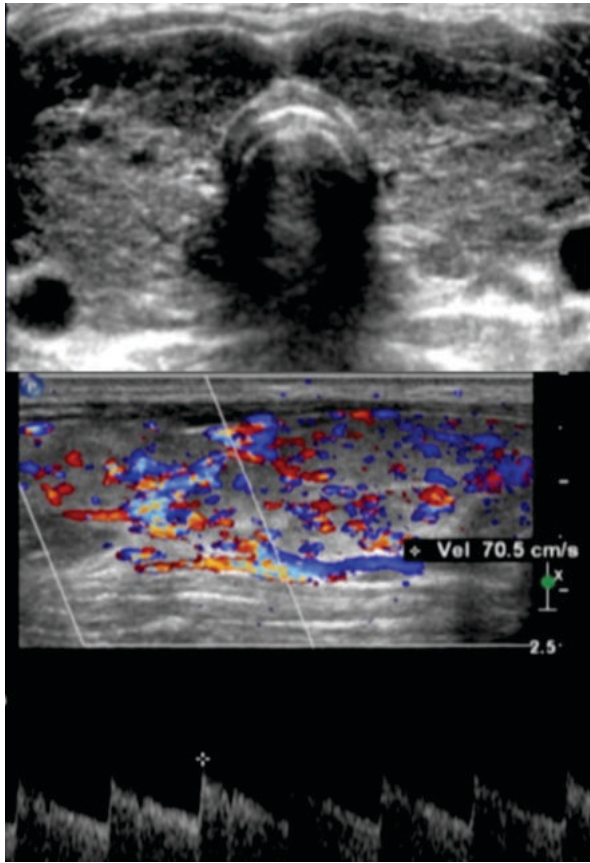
Gray scale appearance and Doppler evaluation of thyroid gland in patients with Graves disease. Gray scale shows diffusely altered echotexture with multiple hypoechoic areas. Doppler evaluation shows high PSV of 70 cm/sec.
